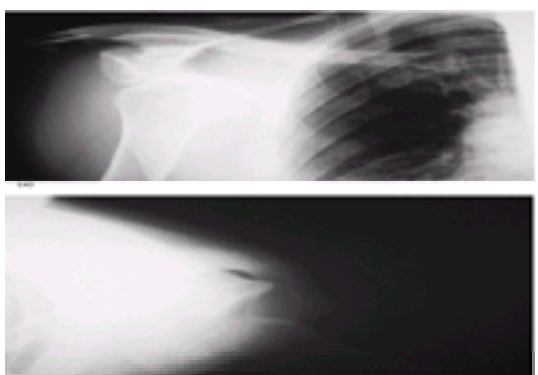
(a) A radiograph demonstrating anterior glenohumeral dislocation. (b) An axillary view of an anterior dislocation of the shoulder with notching of the posterior humeral head. The indentation is described as a Hill–Sachs lesion.
